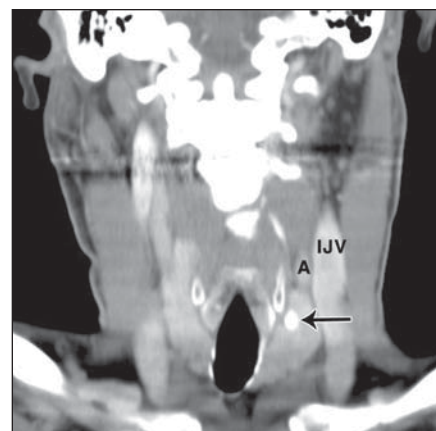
64-year-old man with papillary thyroid carcinoma and cystic and calcified nodal metastasis. Chest CT was initially performed for staging of neuroendocrine tumor of pancreas. Incidental findings in lower neck led to dedicated neck CT study.
